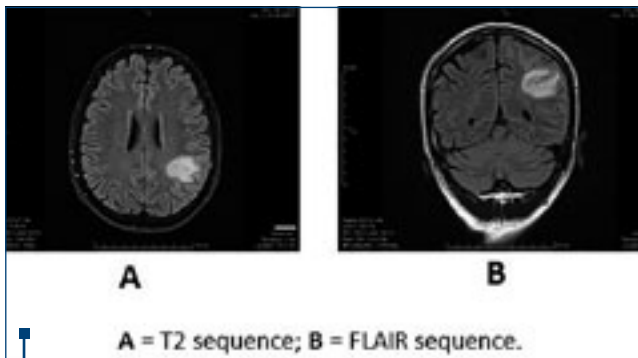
MRI of the brain revealing hyperintense T2 and FLAIR left subcortical temporal and parietal inhomogeneous areas with unrestricted diffusion
